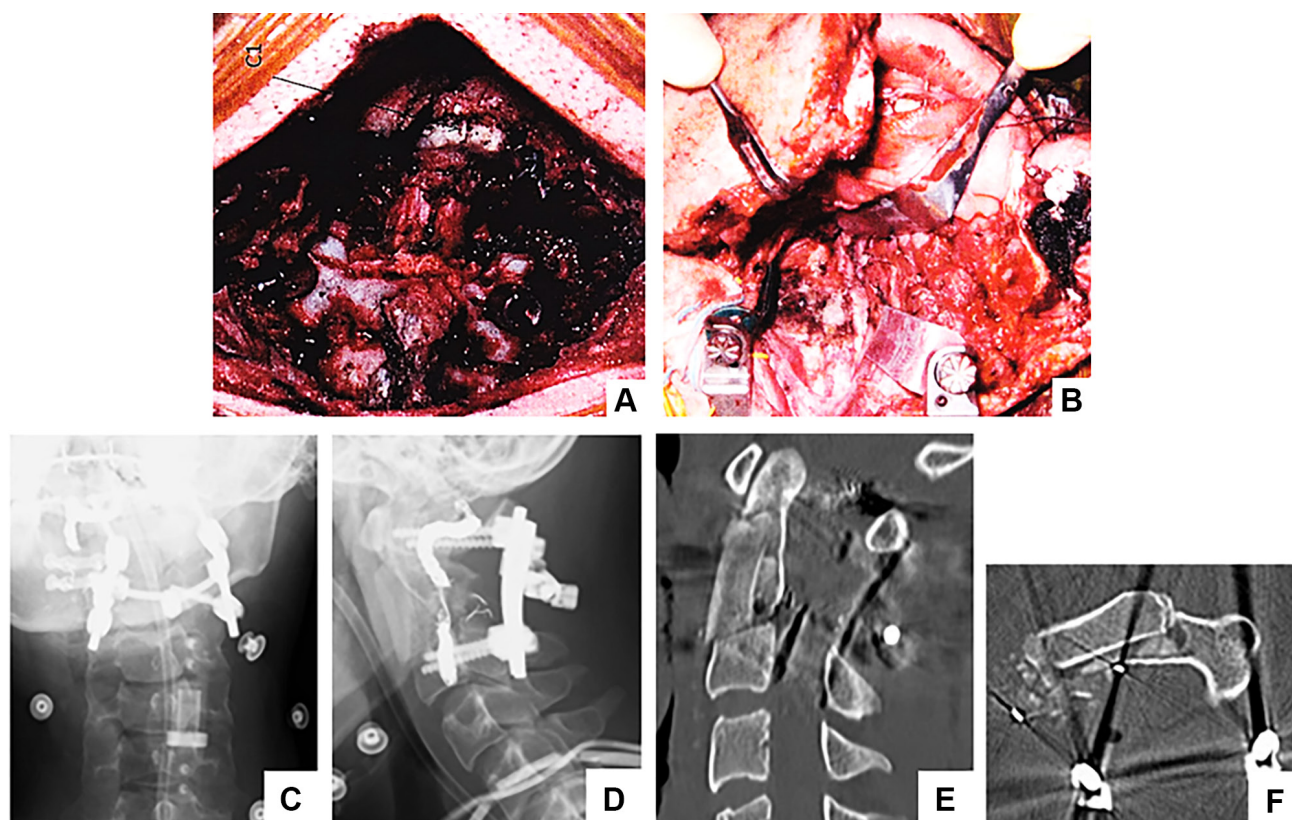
Serial imaging after denosumab therapy. A) Tumor resection and screw insertion using the posterior approach. B) After resection of the anterior vertebral body and lateral vertebral body tumors in an anterior approach. C, D, E, F) Postoperative Xp and computed tomography images showing the screws and grafted bone in the noted positions.
